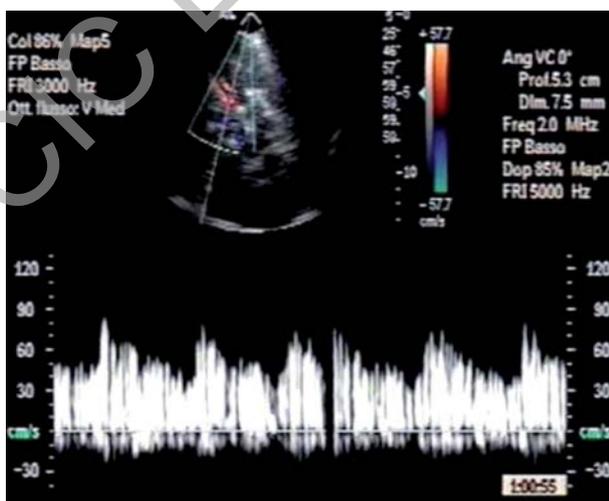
Contrast transcranial colour-coded Doppler detecting a high RLS at rest (high grade permanent shunt).
